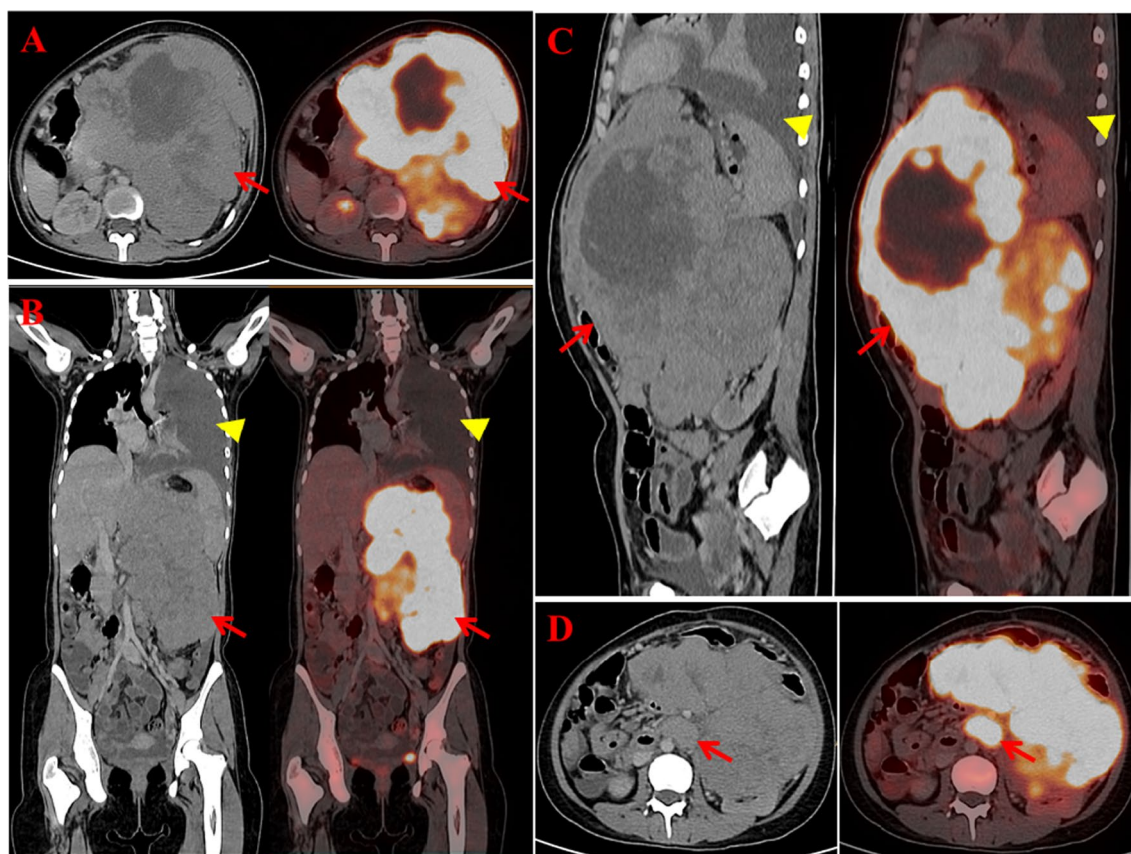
Axial, coronal and sagittal CT and corresponding PET/CT images (A, B and C) showing metabolically active large heterogeneously enhancing lobulated mass (arrow) arising from body and tail of the pancreas with areas of internal necrosis, right pleural effusion (arrowhead) with passive atelectasis of right lung (in coronal and sagittal images). CT and corresponding PET/CT images showing metabolically active paraaortic lymph node (D)
